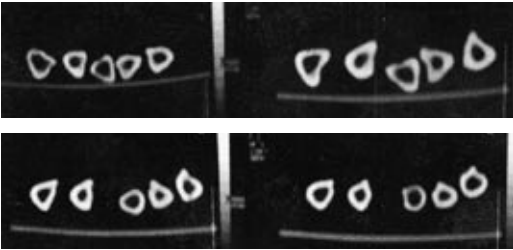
Ulna no. 21. Axial CT scan at 3 cm intervals.
